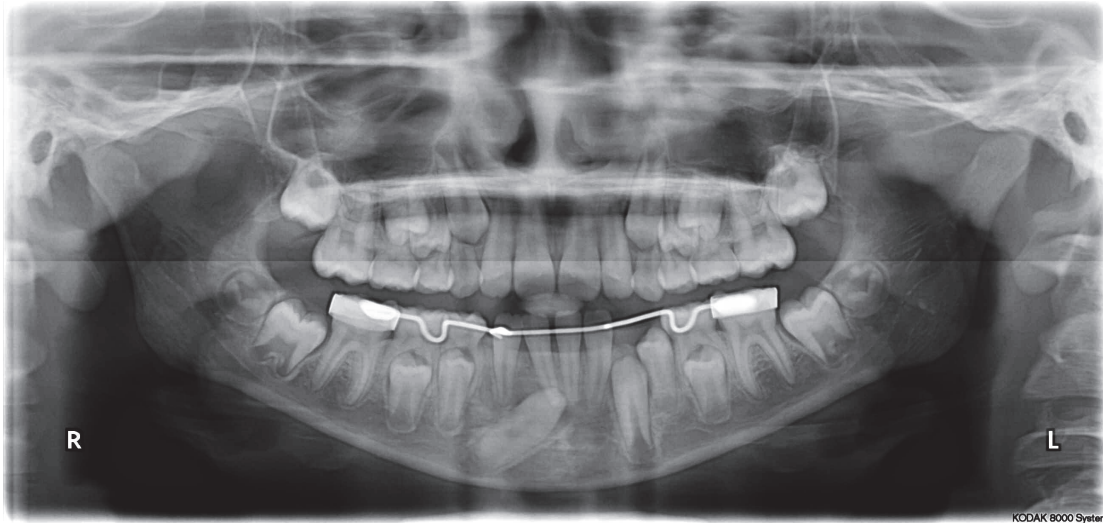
Six months follow-up orthopantomogram.
